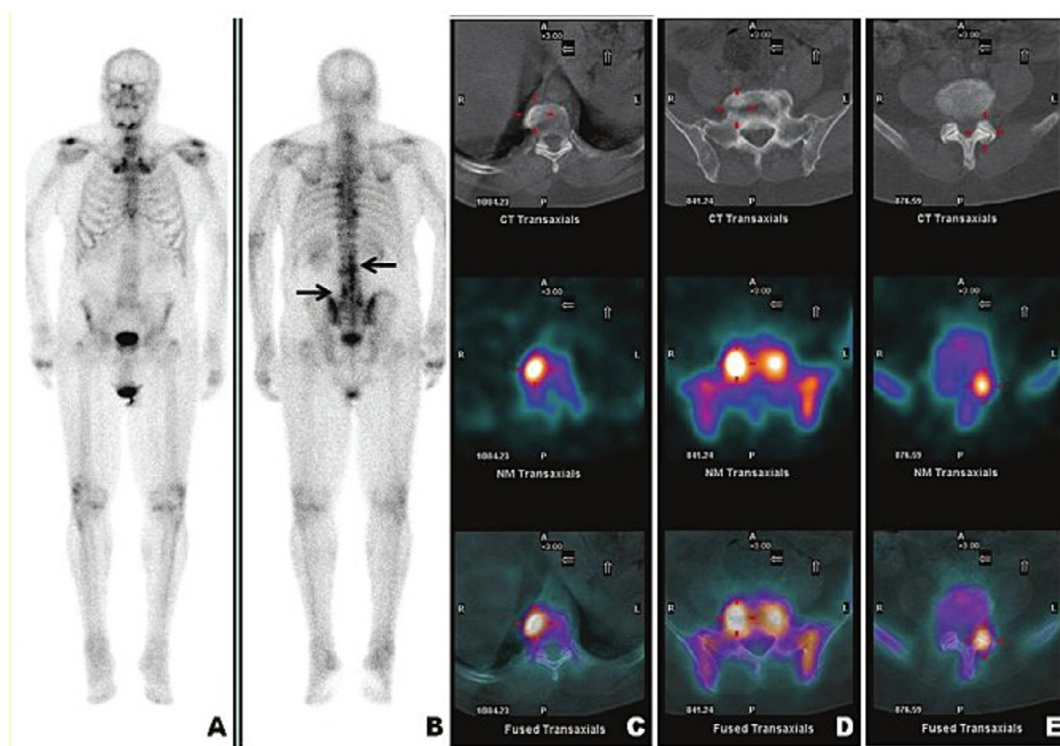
Image A/B: Planar whole body scan images. Images C/D and E indicate separate CT, SPECT and fused SPECT/CT images of selected anatomical spinal areas (Bhargava et al., 2012).
